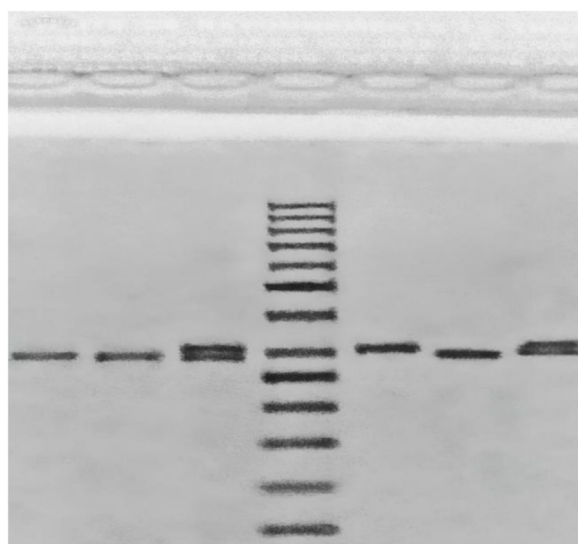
CCR3T51C gene polymorphism and genotypes showing from right to left lane 1, 5 represent CT genotype, lane 2, 6, and 7 represent TT genotype and uncut lane 3 represents CC genotype
